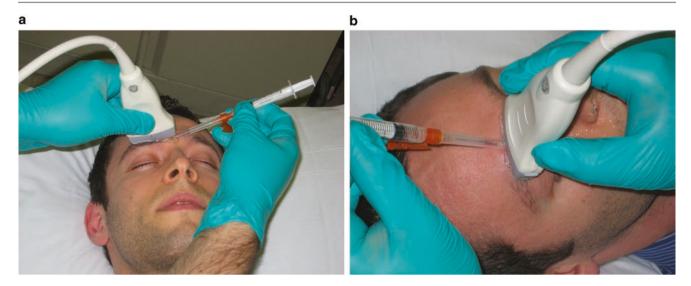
Ultrasound-guided supraorbital nerve injection technique (a) Example of in-plane needle position, (b) example of out-of-plane needle position
